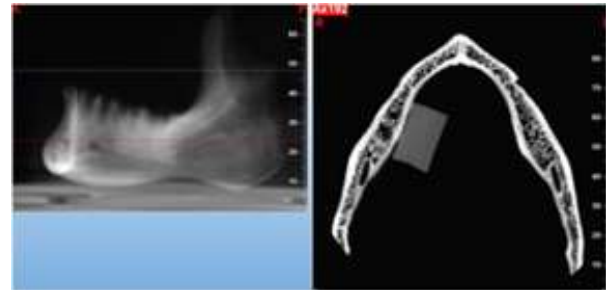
Axial view in the 15×15 cm FOV of NewTom VGi CBCT unit
